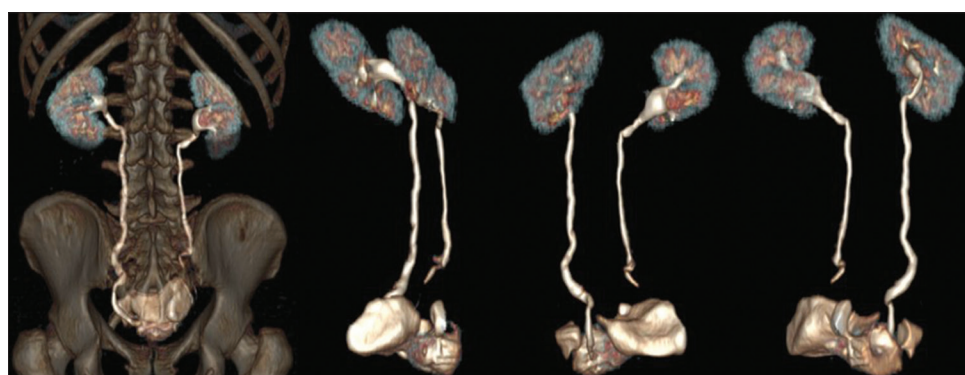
Three-dimensional reconstruction from computed tomography demonstrating multiple posterior wall bladder diverticulum
